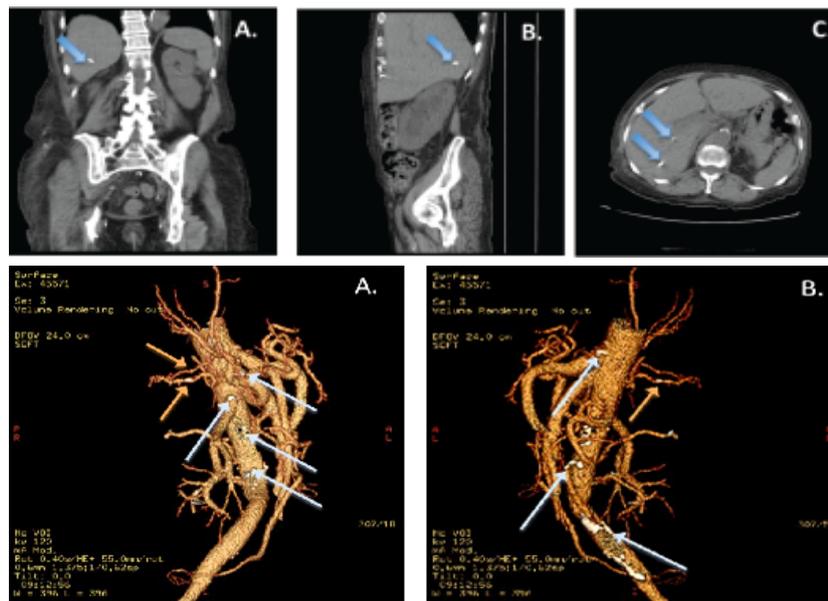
A) Axial B) Coronal C) Parasagittal views from Abdominal CT Scan demonstrates arteriosclerotic plaques on proper hepatic arteries (“Blue Arrows”).
